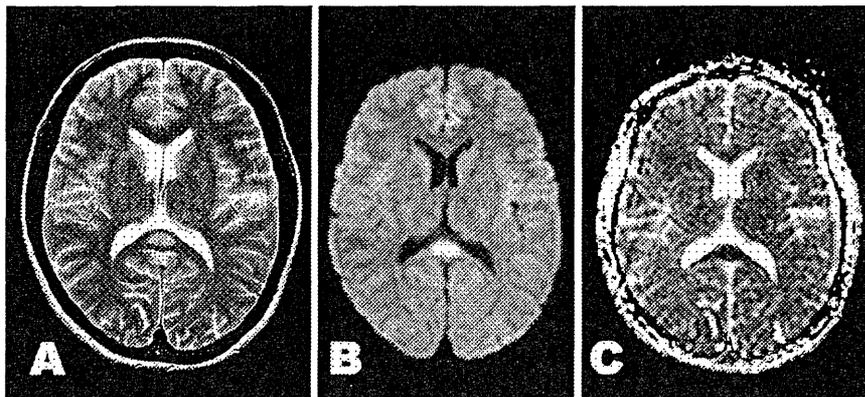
A transient splenial lesion on MRI. A) T2-weighted imaging. B) DWI. A hyperintense lesion was found in the callosal splenium. C) The ADC map showed a hypointense splenial lesion.
